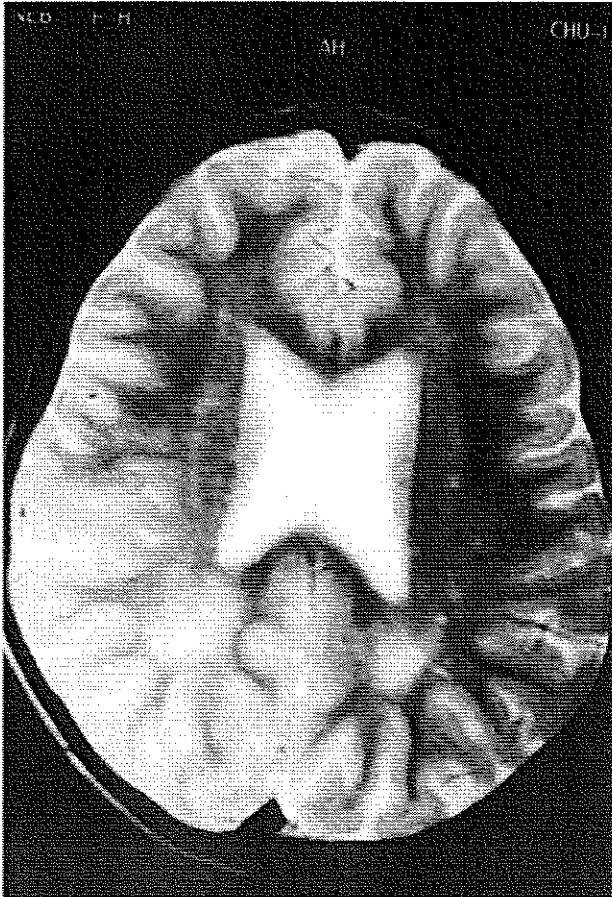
T<sub>2</sub>-weighted magnetic resonance image of the older child showing abnormal hypersignals in the white matter located behind the occipital horns.
